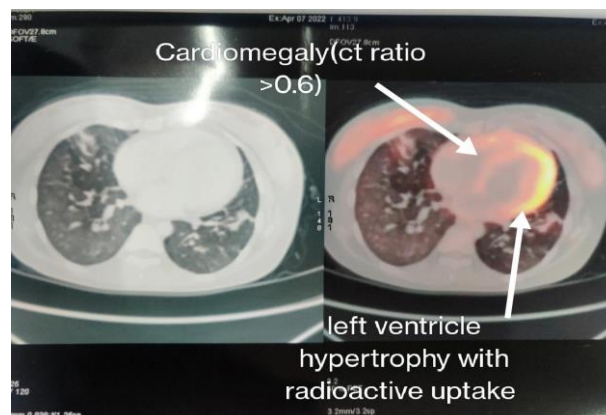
Cardiomegaly (increased CT ratio).
